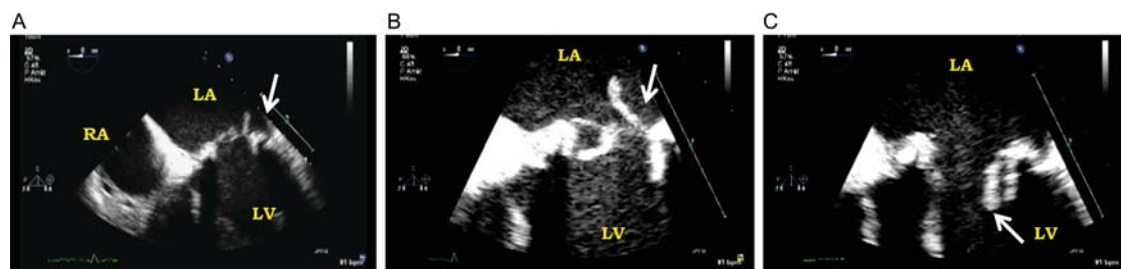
Transoesophageal echocardiography showing a large and mobile vegetation (arrows) on a bioprosthetic mitral valve moving from the left atrium (A and B) to the left ventricle (C) through the prosthesis. LA, left atrium; LV, left ventricle; RA, right atrium.
